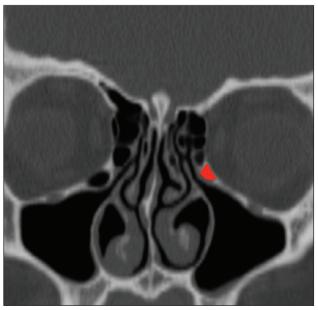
Coronal CT scan showing inferomedial strut of bone that is preserved between the medial orbital wall and inferior orbital walls.
